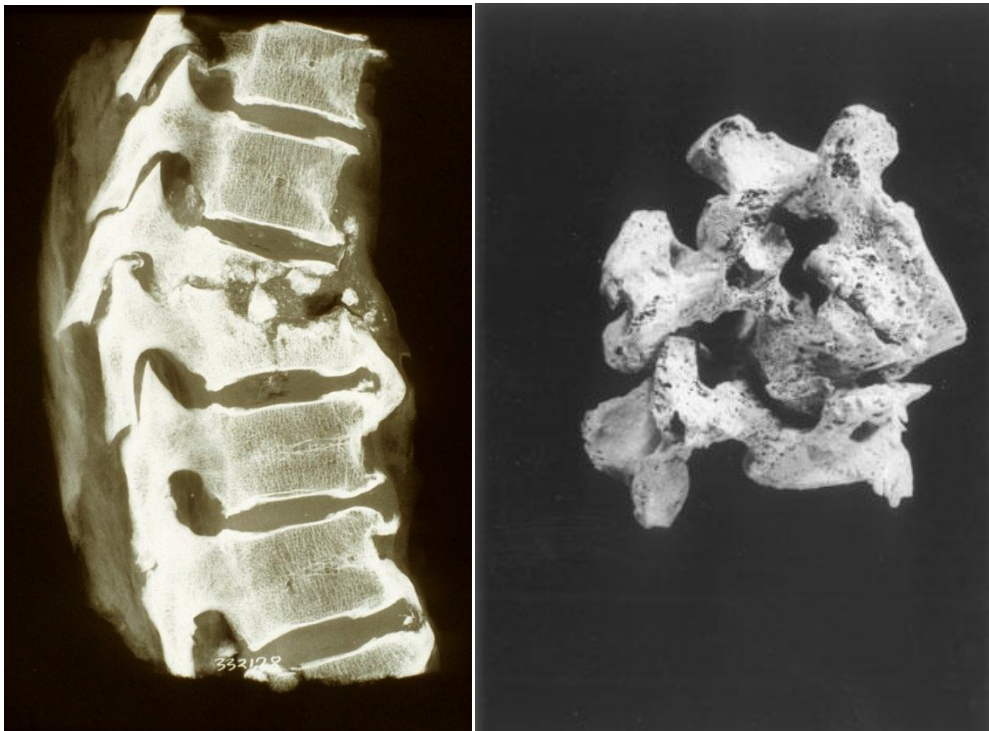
(Left) Clinical X-Ray of vertebral destruction caused by TB. Photo by Bruce Ragsdale.
